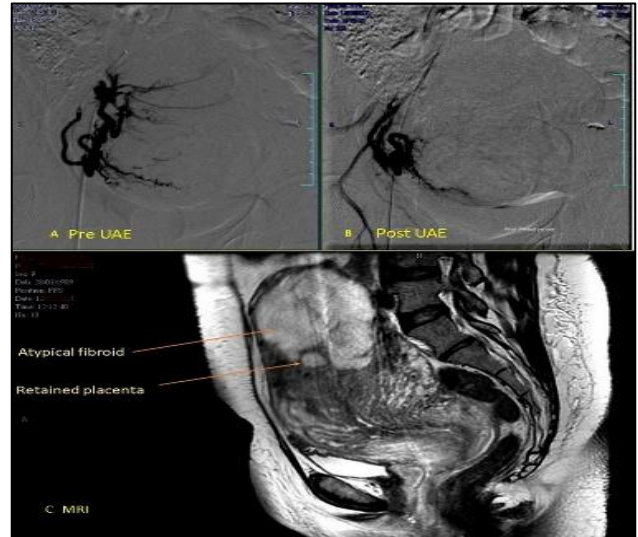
(A-C): Uterine artery embolization, before embolization, after embolization and MRI.
